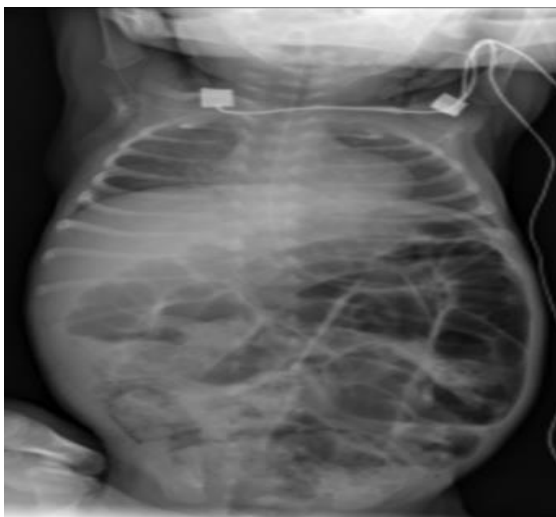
Erect X-ray abdomen: showed multiple dilated bowel loops.
